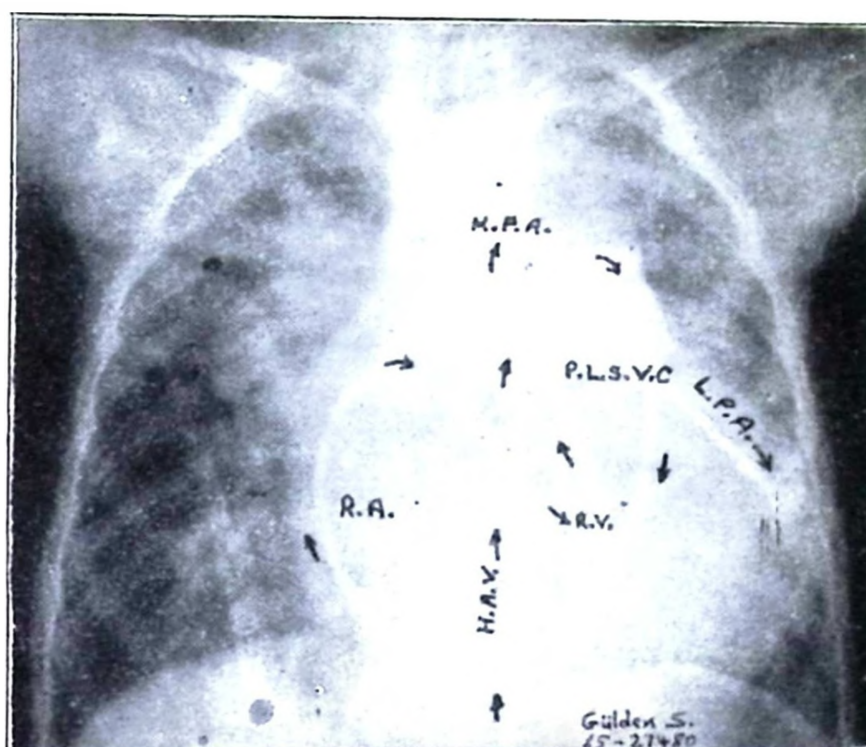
Posteroanterior and lateral roentgenograms showing the position of the catheter, which follows the hemiazygos vein, persistent left superior vena cava, coronary sinus, right atrium, right ventricle, main pulmonary artery and left pulmonary artery.
